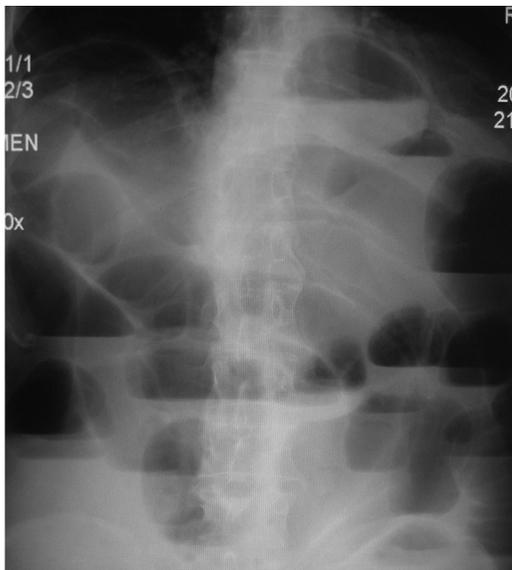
Upright x-ray study demonstrating a small bowel obstruction with multiple air fluid levels. From https://commons.wikimedia.org/wiki/File:Upright_X-ray_demonstrating_small_bowel_obstruction.jpg.
